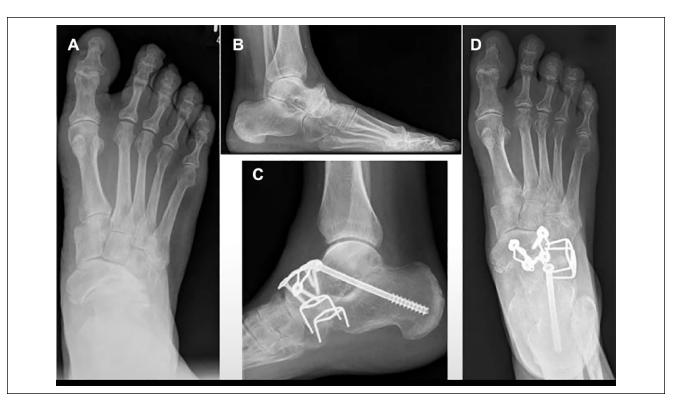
Preoperative (A) anteroposterior and (B) weightbearing lateral radiographs of Müller-Weiss disease. Postoperative radiographs (C, D) showing triple arthrodesis using plate, screws, and staples for fixation. Reproduced by permission from Doyle et al.⁷
